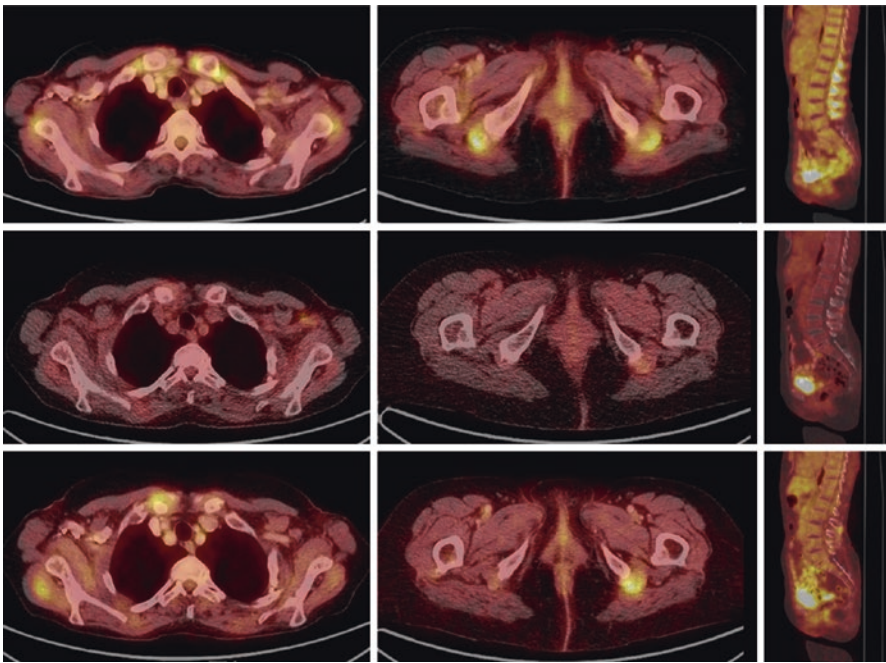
FDG-PET/CT images of axial and sagittal slices from a unique patient. Signs of disease are present in the region of sternoclavicular joints (*left column*), ischiogluteal bursae (*middle column*) and lumbar spinous interspaces (*right column*). The upper row represents the status prior to steroid therapy and is compared with findings after therapy as presented in the middle row. The lower row demonstrates PMR relapse two years after termination of steroid therapy. Together with laboratory measurements showing the patient's increase in concentration of CRP and elevated FW, an FDG accumulation was observed around the right sternoclavicular joint, around the left ischiogluteal region and in one lumbar spinous interspace
